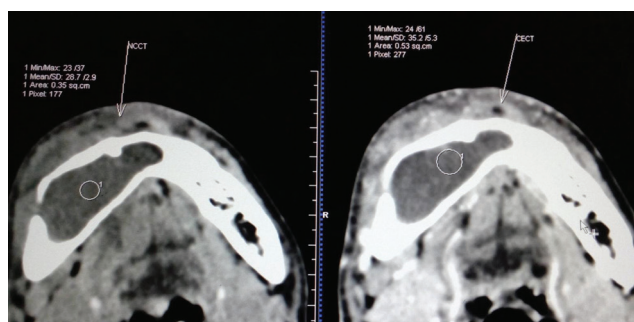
Plain and contrast axial CT Scan showing Ameloblastoma - buccolingually expanding enhancing lytic lesion with cortical destruction in body of mandible on right side
